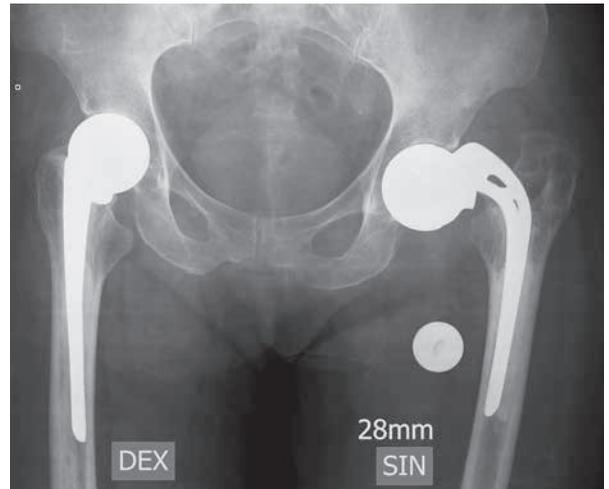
Pelvic X-ray- migration and angular deformity of the left unipolar prosthesis and malposition of the right prosthesis
